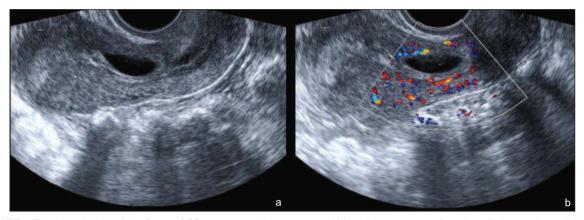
The ultrasonic views of the 7th case; a) GS was seen on the lower segment, b) Uterine lower segment of anterior wall's increased vascularization pattern. GS: Gestation sac.
